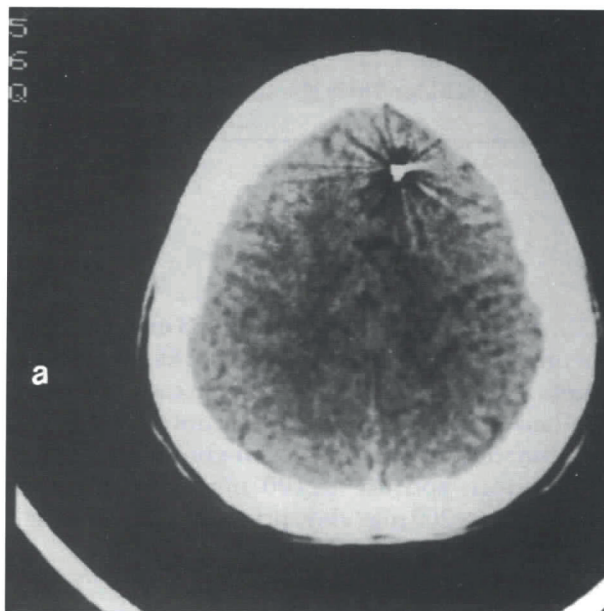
Preoperative CT scan showing the needle in the frontal region with the surrounding hypodense area. Upper end of the needle (a), and deeper portion of the needle (b).
